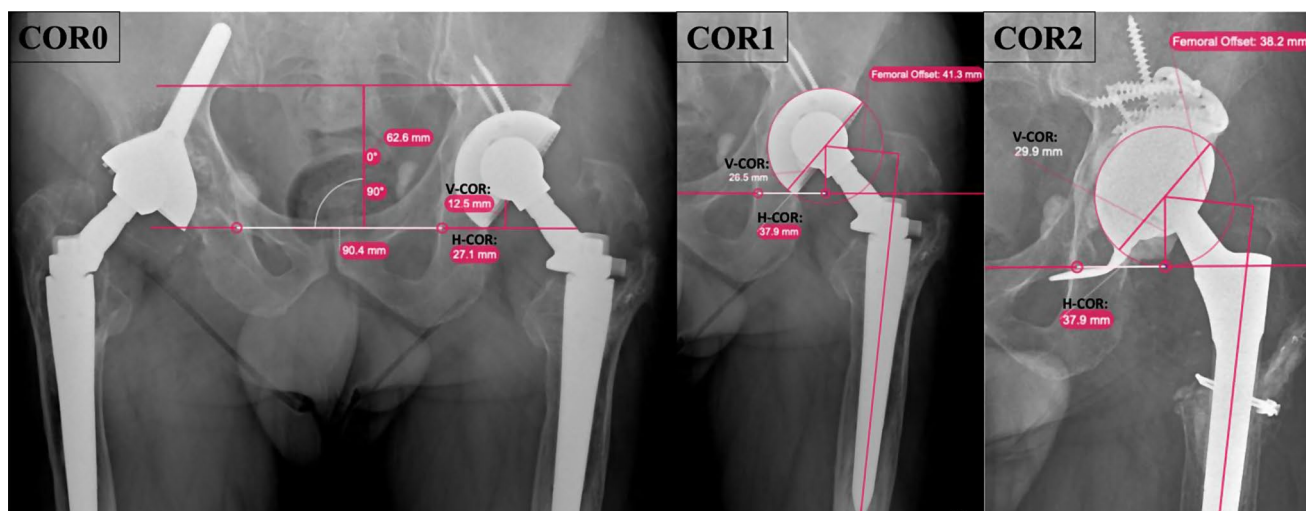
COR analysis of the vertical (V) and Horizontal (H) CORs relative to radiographic U of the native hip (COR0), the primary implant before explantation (COR1), and the revision implant (COR2). Native hip COR was determined according to the Pierchon's method
